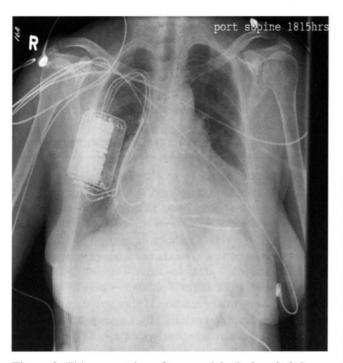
This x-ray, taken after a week in the hospital shows an implantable defibrillator/pacemaker. The pulmonary edema has mostly cleared up.
